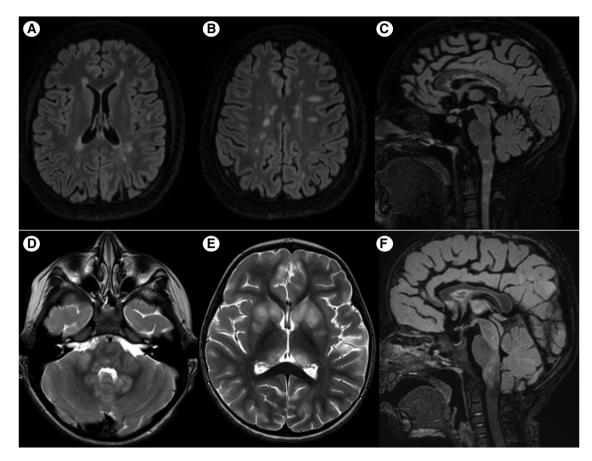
The axial fluid-attenuated inversion recovery (FLAIR) images (A, B) shows multiple oval-shaped periventricular and deep white matter lesion in perivenular distribution. The sagittal FLAIR image (C) shows multiple small demyelinating plaques at the undersurface of the corpus callosum, producing the ependymal "dot and dash" sign. Similar lesions are also noted at the upper cervical cord. The axial T2-weighted images (D & E) show fluffy hyperintense lesions at pons, bilateral middle cerebellar peduncles, dentate nucleus, bilateral striatum, and posteromedial thalami. The sagittal FLAIR image (F) shows the involvement of the brainstem (midbrain, dorsal pons, and medulla).
